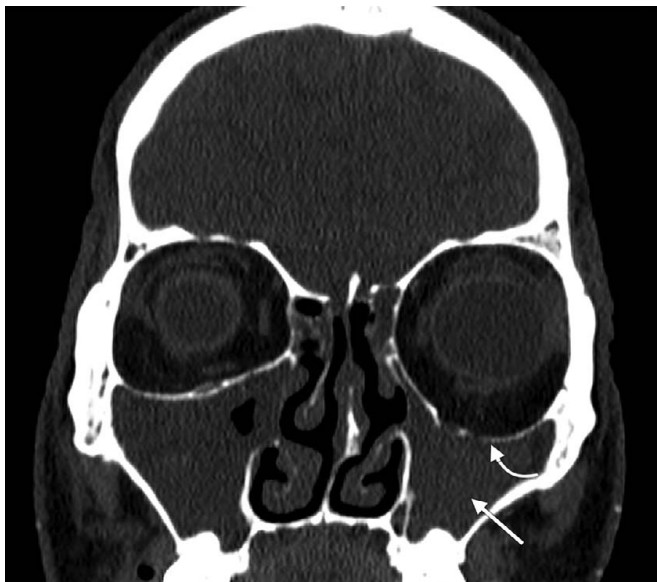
Silent sinus syndrome. Coronal computed tomography (CT) shows an opacified left maxillary antrum with maxillary sinus volume loss (arrow). The orbital floor is inferiorly positioned (curved arrow) with secondary increase in orbital volume, resulting in enophthalmos.
